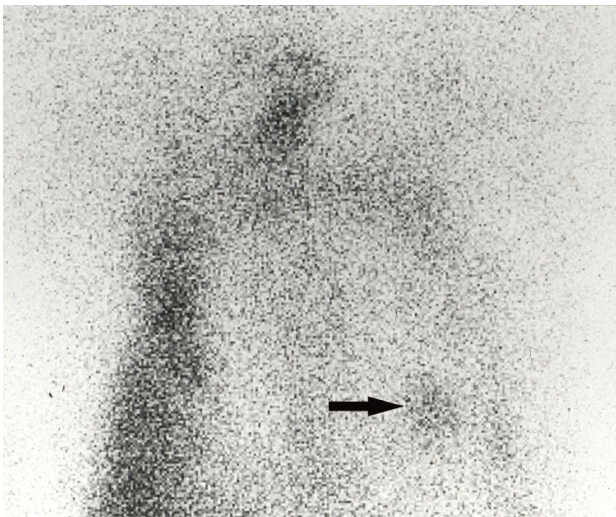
Gallium scintigraphy showed hot spot in left middle abdomen (black allow)
